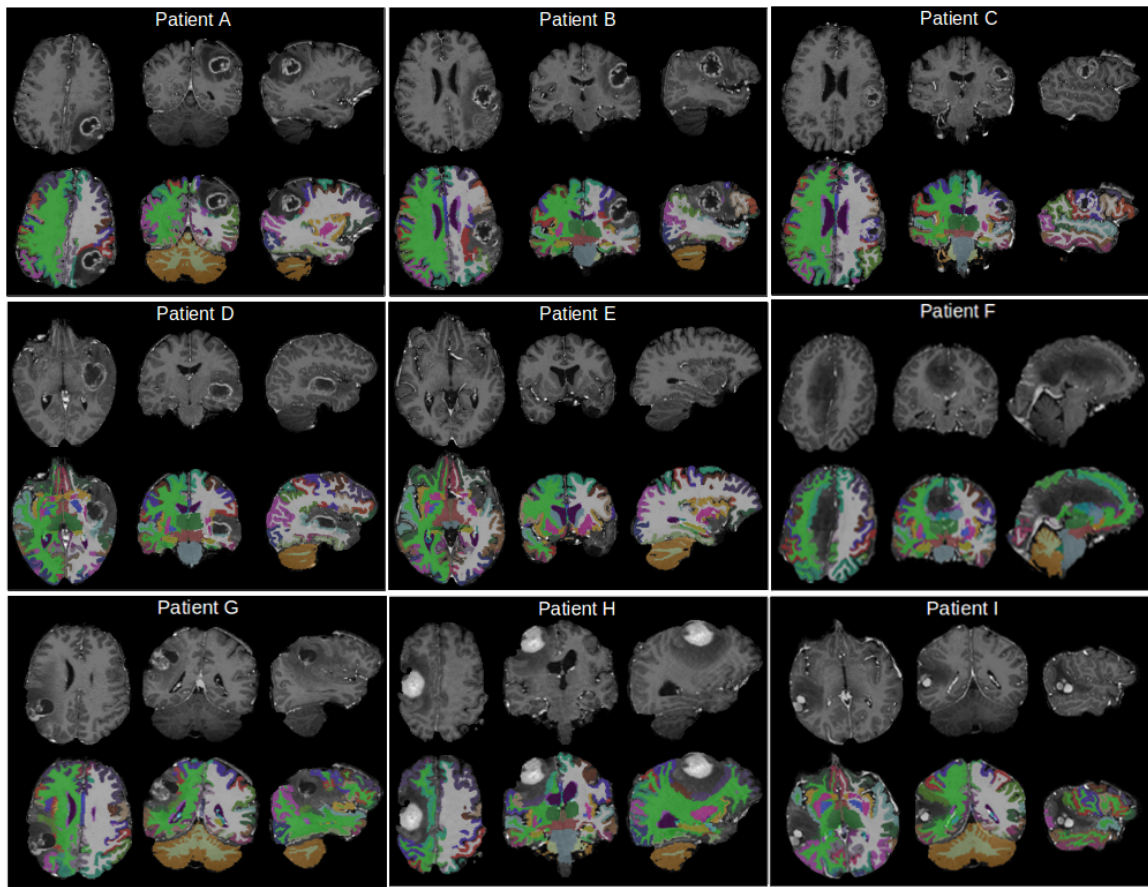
T1-weighted axial, coronal and sagittal cuts for all patients, showing the region affected by the tumour. In the first row plain T1-weighted images are shown and in the second row the correspondent parcellation obtained with freesurfer is displayed.
